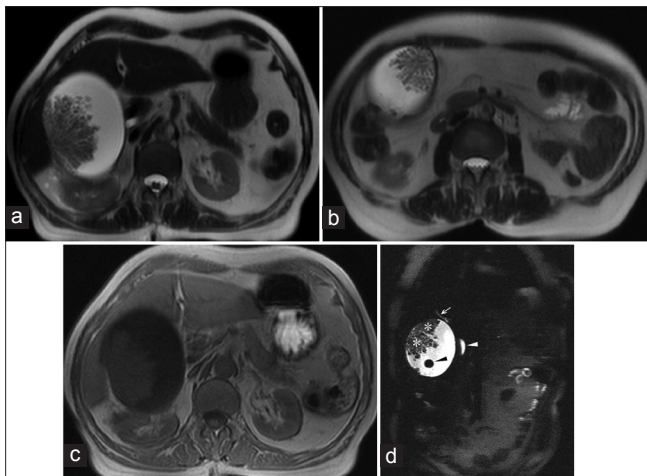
MRI shows frond-like intraluminal gallbladder lesions. Compared with liver, the masses display high signal on T2w image (a, b), and low signal on T1w image (c). Intrahepatic bile duct (white arrow) and common bile duct (white arrowhead) were not dilated on the thin-slab MRCP image (d). Note the villous adenoma (asterisk) and gallstone (black arrow) in the gallbladder
